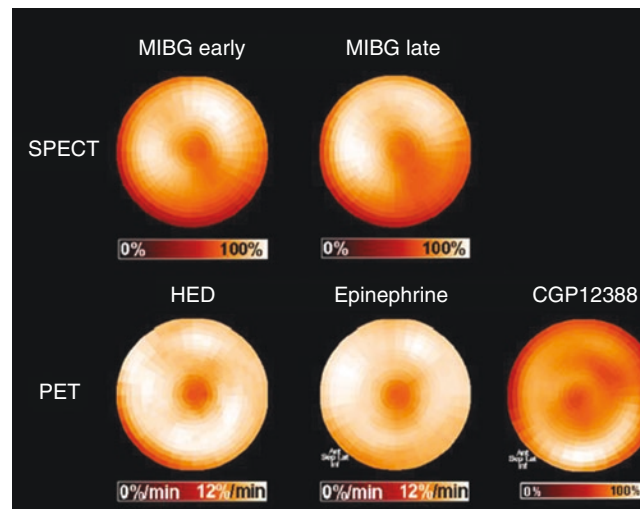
Polar maps of myocardial distribution (center–apex to periphery–base) of *mIBG* from early (15 minutes post-injection) and late (4 hours post-injection) SPECT images of the normal heart for comparison with those of selected ^{11}C -labeled PET tracers also used in assessment of functional status of the sympathetic nervous system. The mechanism of neuronal uptake for HED and epinephrine are the same as for *mIBG*, with the norepinephrine transporter (NET) responsible for
